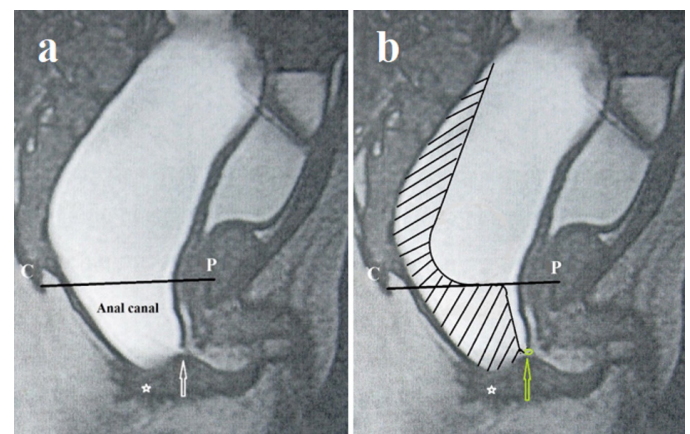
(a) MRI imaging during augmented-pressure distal colostogram in a male with recto-bulbar fistula (arrow). Distal to the pubococcygeal line, a wide-open anal canal is visible. Its blind end is located \approx 2-4 mm from the proposed site of the anal fossa (asterisk). (b) MRI reconstruction scheme with low rectal pressure. The anal canal is closed. Conclusion: Ectopia of the anal canal into the bulbar part of the urethra
